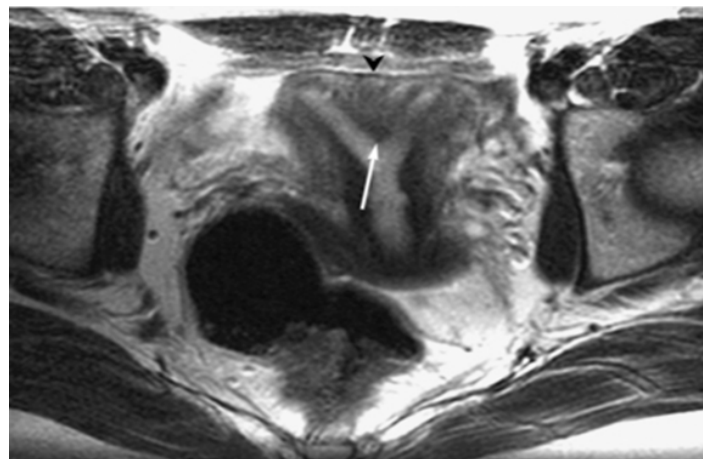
Septated uterus. Axial T2-weighted image demonstrates a partial septum dividing the endometrial cavity (arrow) and a nonclefted uterine fundus (arrowhead).
